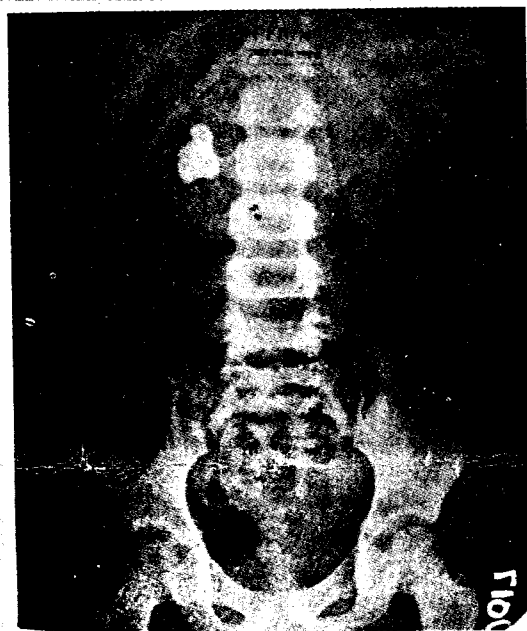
X-ray KUB showing right staghorn calculus
